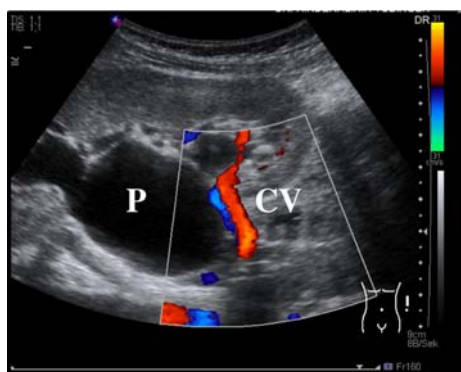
Color Doppler ultrasound (P renal pelvis, CV crossing vessel)
